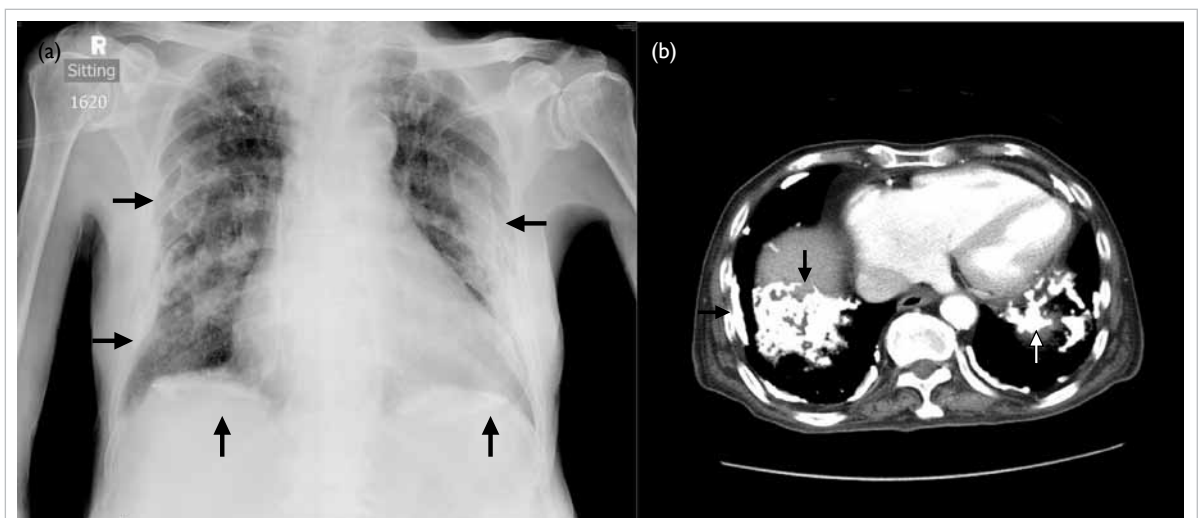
(a) Chest X-ray and (b) computed tomography of the thorax showing calcified pleural plaques and diaphragmatic calcifications bilaterally (arrows)
